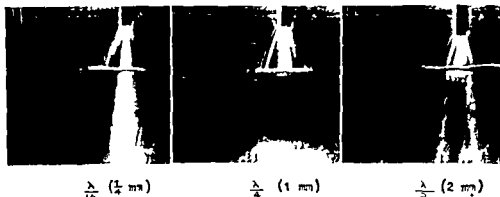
Schlieren photographs demonstrating the transmission of ultrasonics through bone laminae of various thicknesses. Reproduced by courtesy of the Journal of Laryngology
